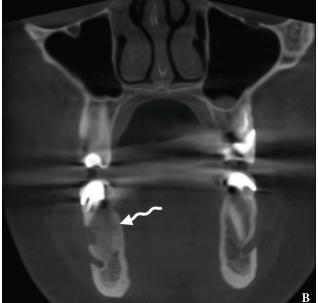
A*, a pre-biopsy coronal CBCT scan showed anterior chamber of mandibular SBC (*arrow*). *B*, a 5-month follow-up coronal CBCT scan demonstrates fulfillment of the anterior chamber by a new bone tissue (waved arrow). Printed with permission and copyrights retained by O.A.N.
